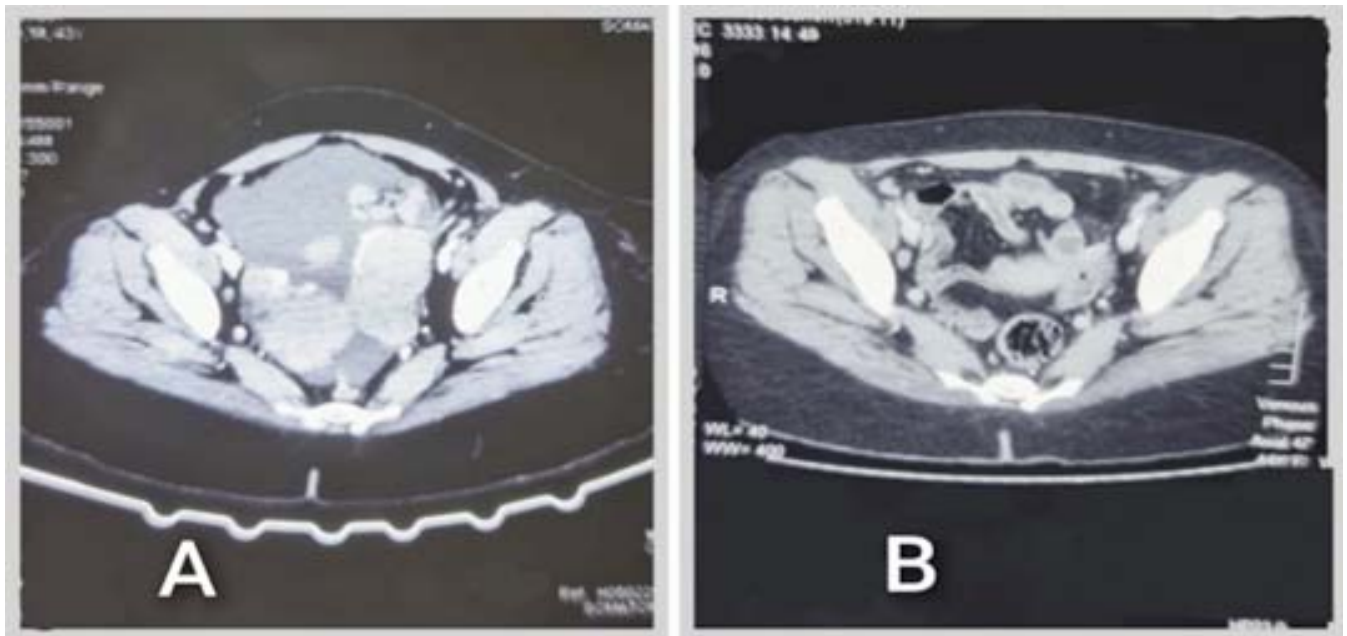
CT scan of the abdomen and pelvis showing bilateral adnexal mass. Before (A) chemotherapy and after (B) chemotherapy.
